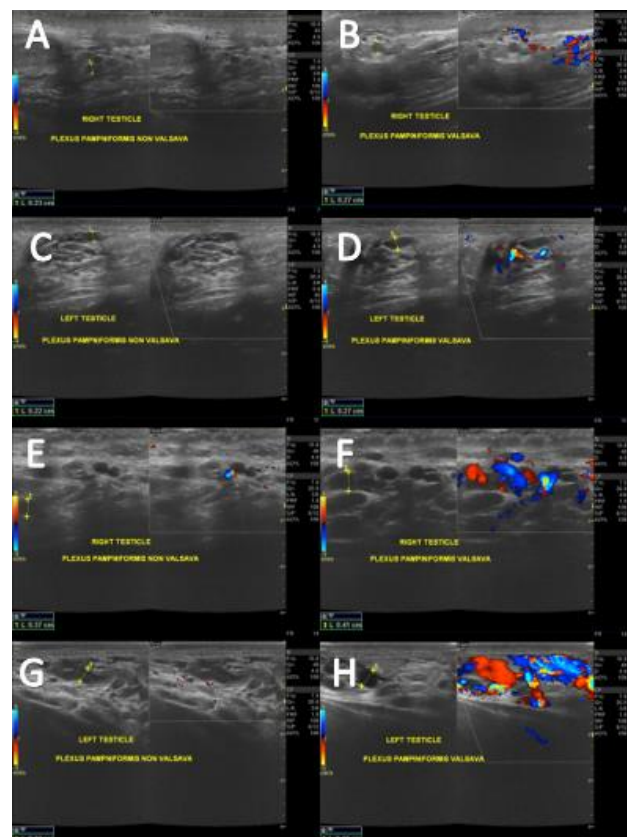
Doppler ultrasound of grade II varicocele. A) is the right testicle and C) is the left testicle. Both showing plexus pampiniform diameter at less than 3 mm in relaxed supine position. Both right (B) and left (D) pampiniform plexus diameter increased at the range of 2-3 mm during Valsava maneuver. Doppler ultrasound of grade III varicocele. E) is the right testicle and G) is the left testicle. Both showing plexus pampiniform diameter more than 3 mm in relaxed supine position. Both right (F) and left (H) pampiniform plexus diameter increased higher than 3 mm during Valsava maneuver
